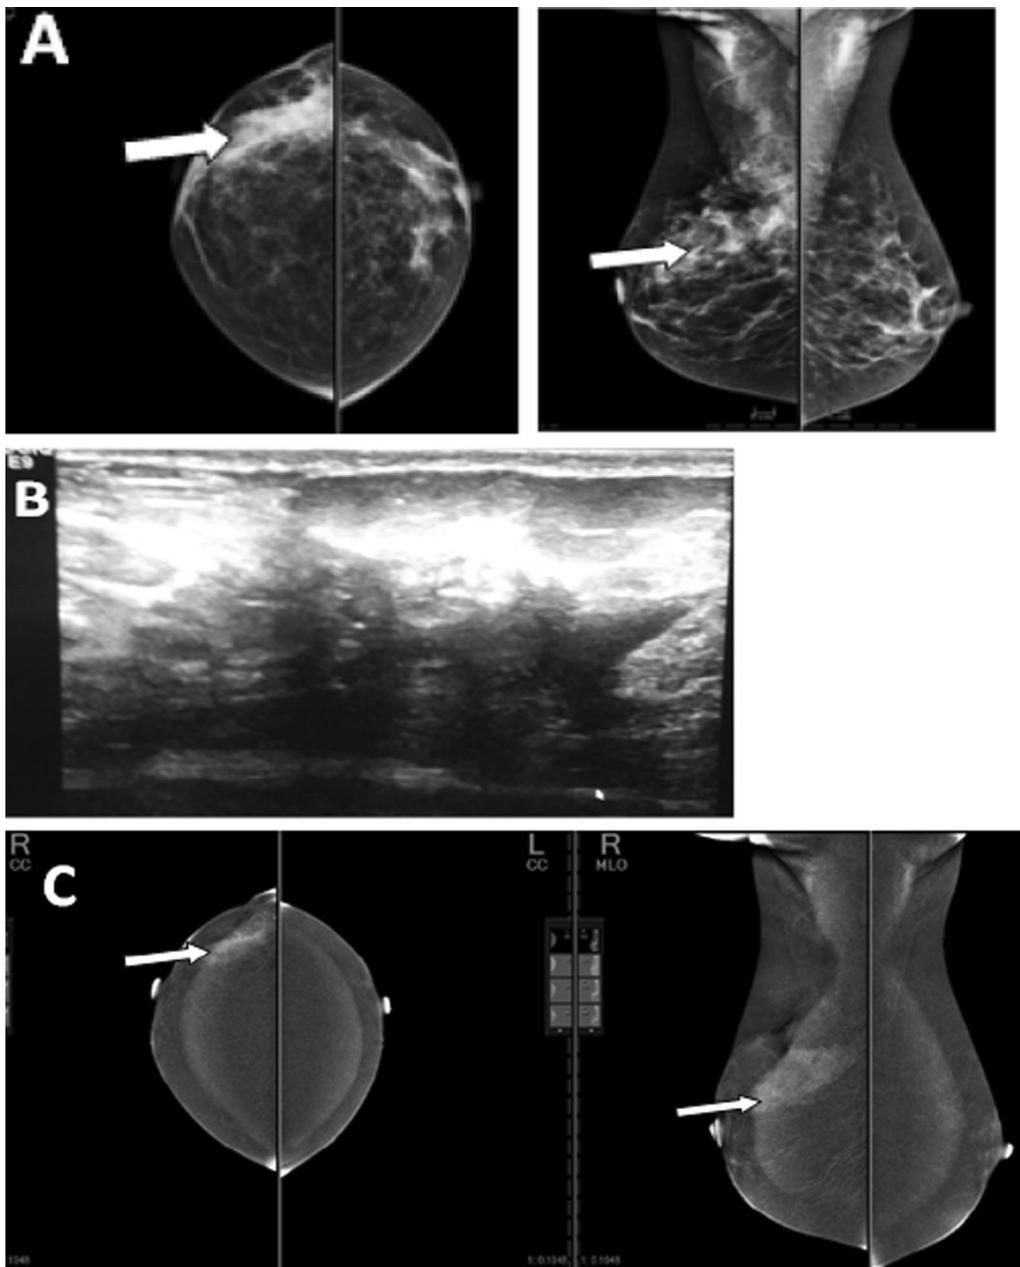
A 40-year-old asymptomatic patient underwent right CBS for DCIS, presenting for annual follow-up. A Mammography (CC and MLO views) revealed: Breast density ACR 'b'; focal asymmetry is seen at right UOQ (white arrow). B Complementary ultrasound revealed: Right operative bed changes and scarring that showed no vascularity detected on color Doppler application. C Contrast-enhanced spectral mammography revealed: an operative bed segmental area of non-mass enhancement at UOQ of the right breast (white arrow). Final Diagnosis: Pathology: DCIS; operative bed recurrence. Final comment: In this case, sonomammography revealed evidence of extensive operative bed scarring. CESM revealed operative bed recurrence as well as showing the true extent of the lesion
